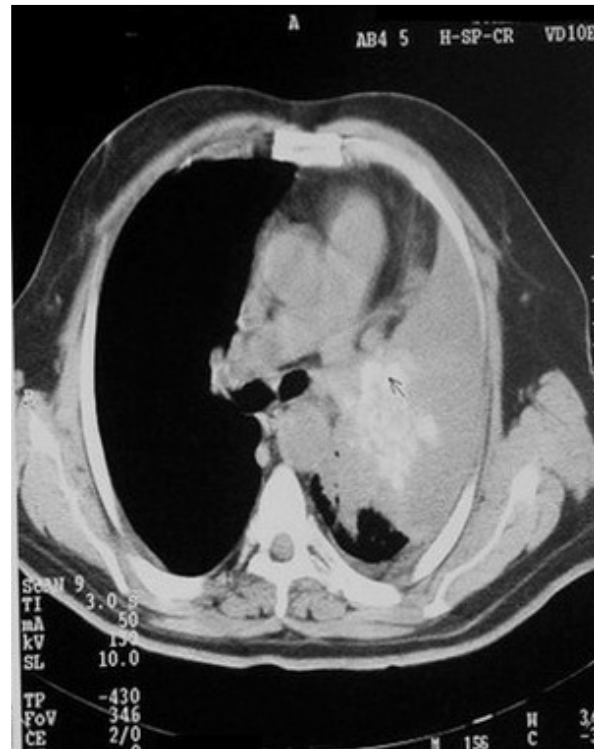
Thoracic CT-scan
